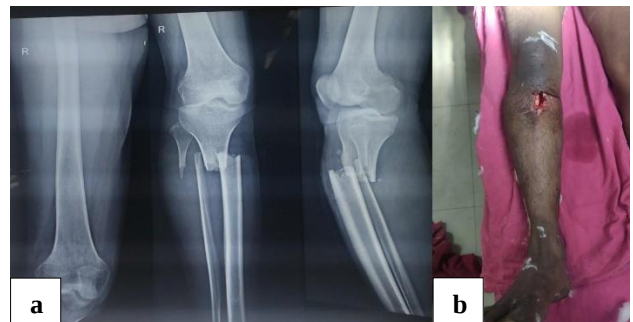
(a and b): Pre-operative X-ray and clinical photo.
